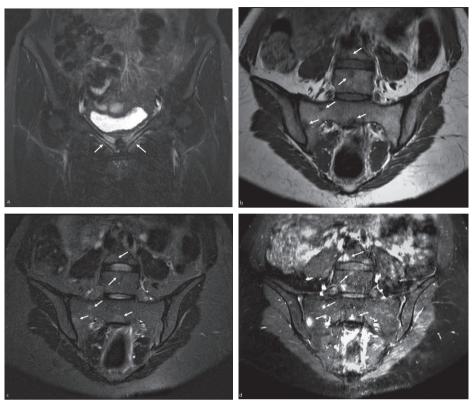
A: A coronal STIR MR image shows bone marrow edema and periosteal reaction of the pubic bones (arrows). The pubic symphysis exhibits sclerosis of the subchondral bone. B: A T1w coronal oblique MR image shows hypointense foci with indistinct margins in the sacrum and L5 and L4 vertebral bodies (arrows). C: On a coronal STIR MR image at the same level as above these foci are barely visible. D: On a contrast-enhanced T1w MR image with fat suppression the lesions present significant enhancement (arrows).
